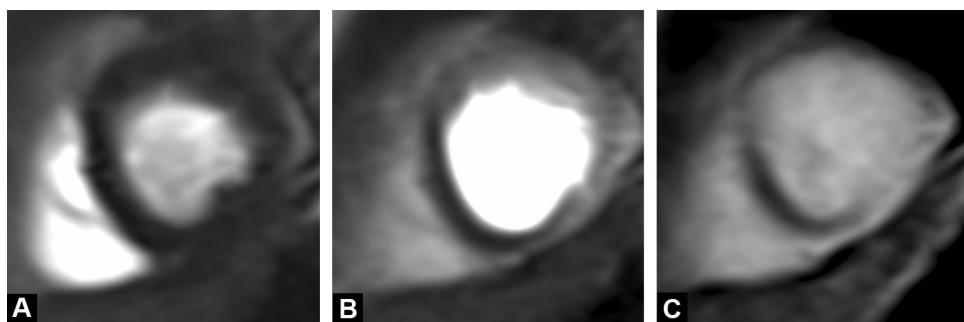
Stress MRI imaging under regadenoson in a young adult with stenosis of the left anterior descending artery. Three sequential images are shown. A. Gadolinium chelate just reached the left ventricle cavity and no myocardial uptake of contrast material is visible. B. While normal myocardium enhances, septum and posterior wall perfusion is obviously decreased. C. Hypointensity, indicating ischemia, persisted during several cardiac cycles.
